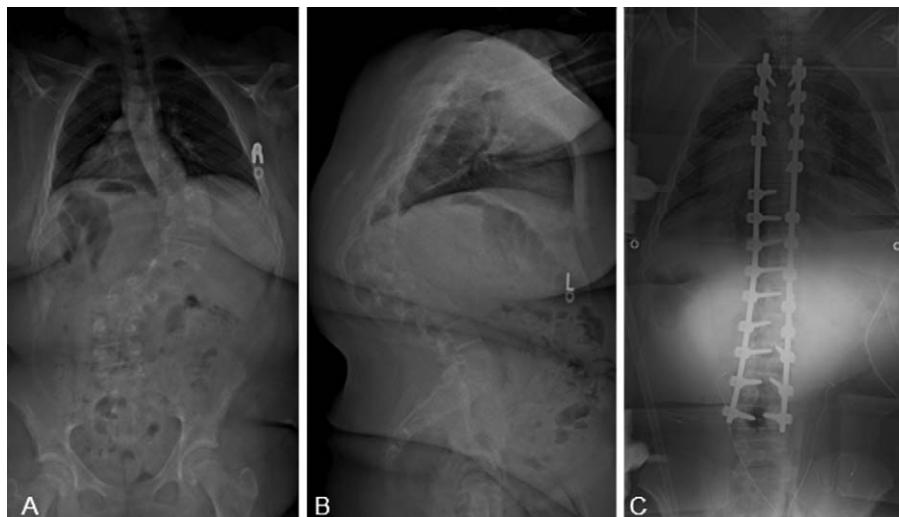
Standing posteroanterior (A) and lateral (B) radiographs of a 13-year-old female with a maximum coronal Cobb of 70° and a sagittal Cobb of 90°. Intraoperative posteroanterior radiograph (C) demonstrating reduction of the coronal deformity with an all pedicle screw construct from T3 to L4.
